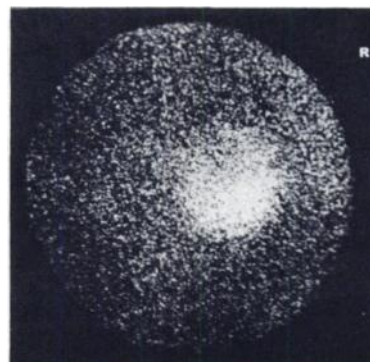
Preoperative posterior adrenal scintigram at 6 days after selenonorcholesterol (Se-75). Tumor shows good uptake, with none in left adrenal.
